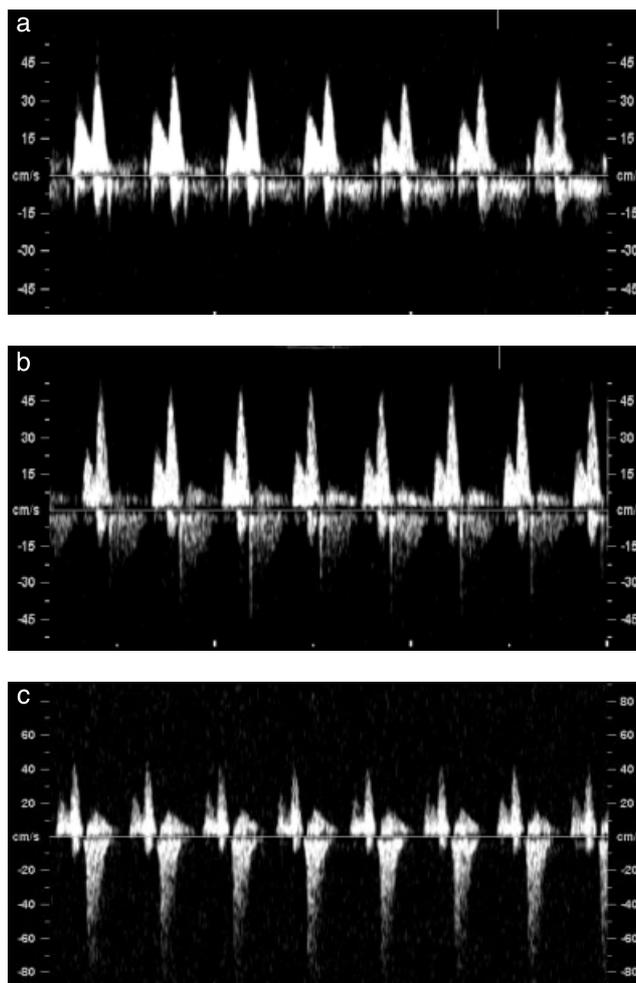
Ultrasound images showing the Doppler flow profile in the tricuspid valve with (a) no regurgitation during systole, (b) a short reverse 'spike' generated by the closure of the valve cusp and the jet produced by aortic or pulmonary arterial blood flow, and (c) regurgitation during approximately half of systole and with a velocity of more than 60 cm/s.
